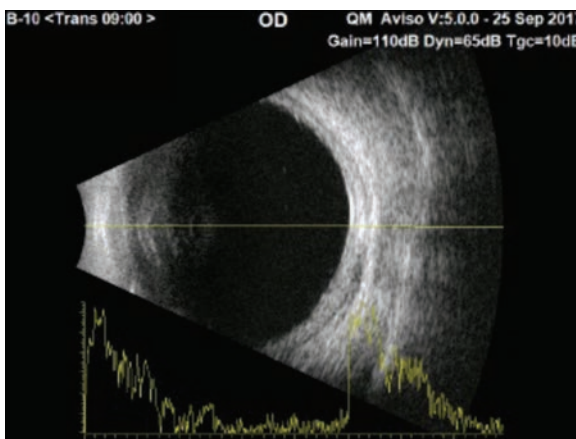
B-scan ultrasound demonstrating thickened choroid with fluid in sub-Tenon's space.
